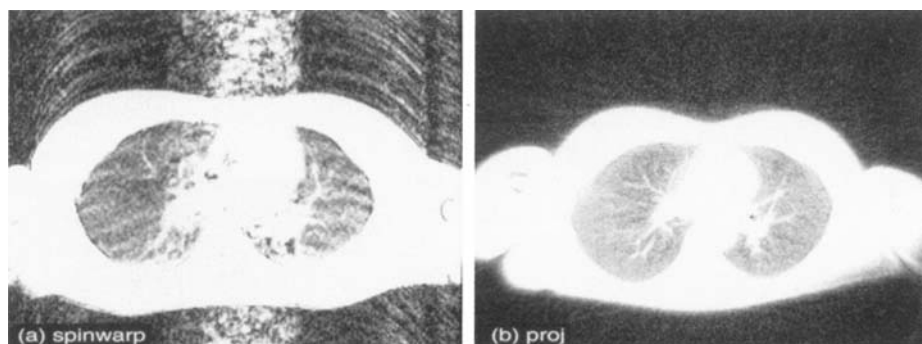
Comparison of images obtained with (a) conventional T1-weighted multislice spin-warp: TR = 600 ms, TE = 20 ms, 256 \times 4 NEX, scan time 8 min using respiratory compensation; and (b) multislice Hadamard projection reconstruction: TR = 200 ms, TE = 0.1 ms, 512 views \times 8 NEX, scan time 4 min. The lack of motion artifacts with the PR sequence is critical to the successful visualization of lung parenchyma due to the low parenchymal signal.
